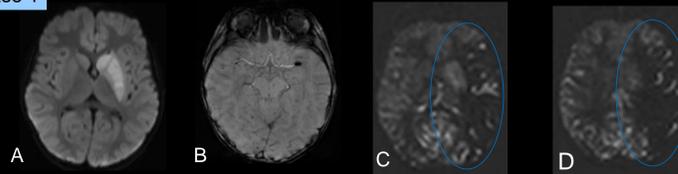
3-year-old boy with history of prior cardiac surgery. DWI (A) shows an acute infarct in the left basal ganglia and SWI (B) demonstrates a clot in the distal left M1 branch. PASL images (C,D) demonstrate large penumbra (hyperperfusion) through the left MCA territory, much larger than infarct on DWI. Hyperperfusion noted in left basal ganglia (C,D).
